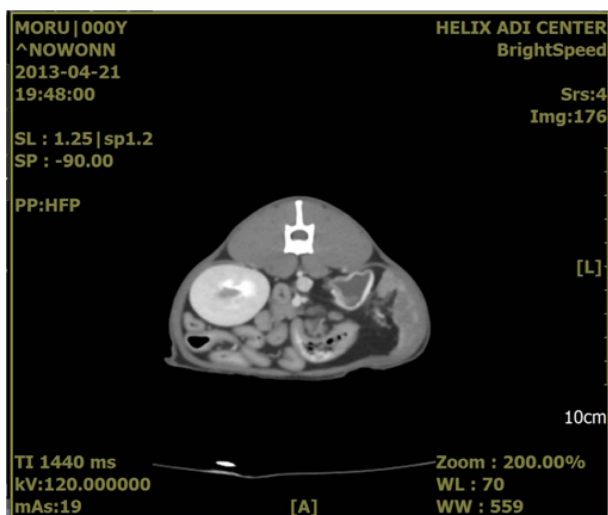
Postcontrast computed tomographic examination revealed fluid-filled cystic lesion in the left side of the abdomen, suggesting the renal degeneration.
